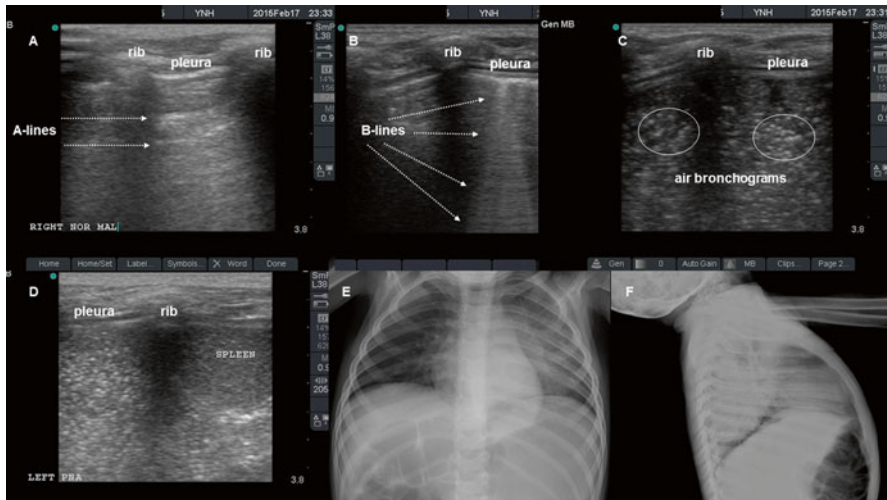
Ultrasound findings in a toddler with a left lung consolidation. Image (a) shows the normal appearance of the right lung with the presence of horizontal a-lines (reverberation artifacts). Images (b–d) are left sided mid-axillary views moving from a more cephalad to caudal position. Image (b) depicts pathologic deep vertical B-lines or “comet tails” that dive all the way down to the bottom of the screen. Image (c) shows air bronchograms seen in transverse orientation represented by prominent punctate hyperechoic spots. Image (d) shows the “hepatization” of lung created by consolidation directly above the spleen. Images (e, f) are the corresponding AP and Lateral chest radiographs (note that the left lung consolidation is best seen on the lateral view)
